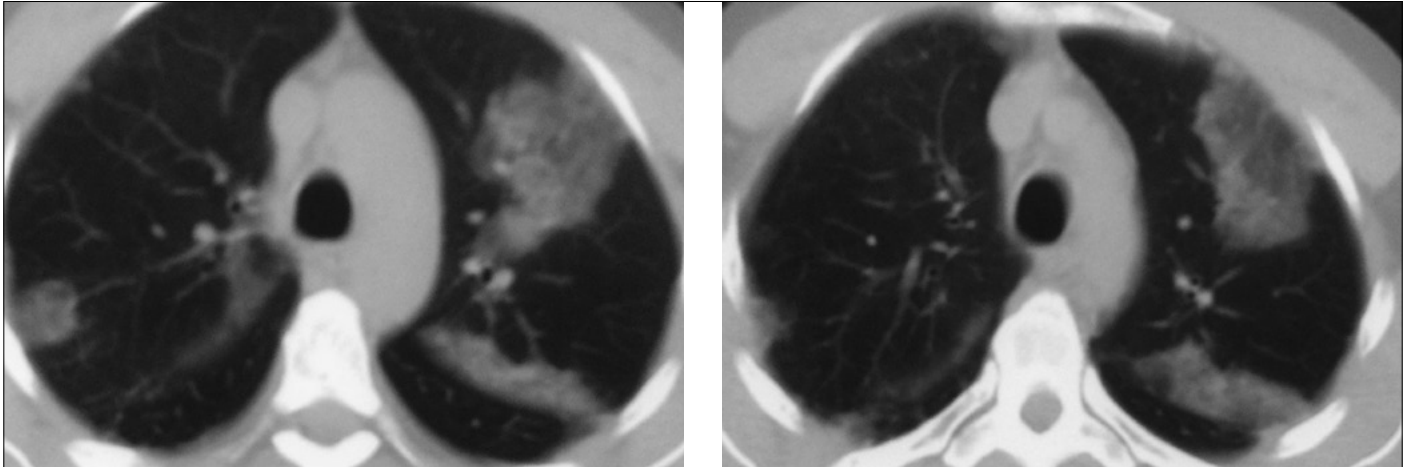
Case 17: A thorax CT image showing non-homogeneous bilateral infiltrates in the periphery and upper lobe
